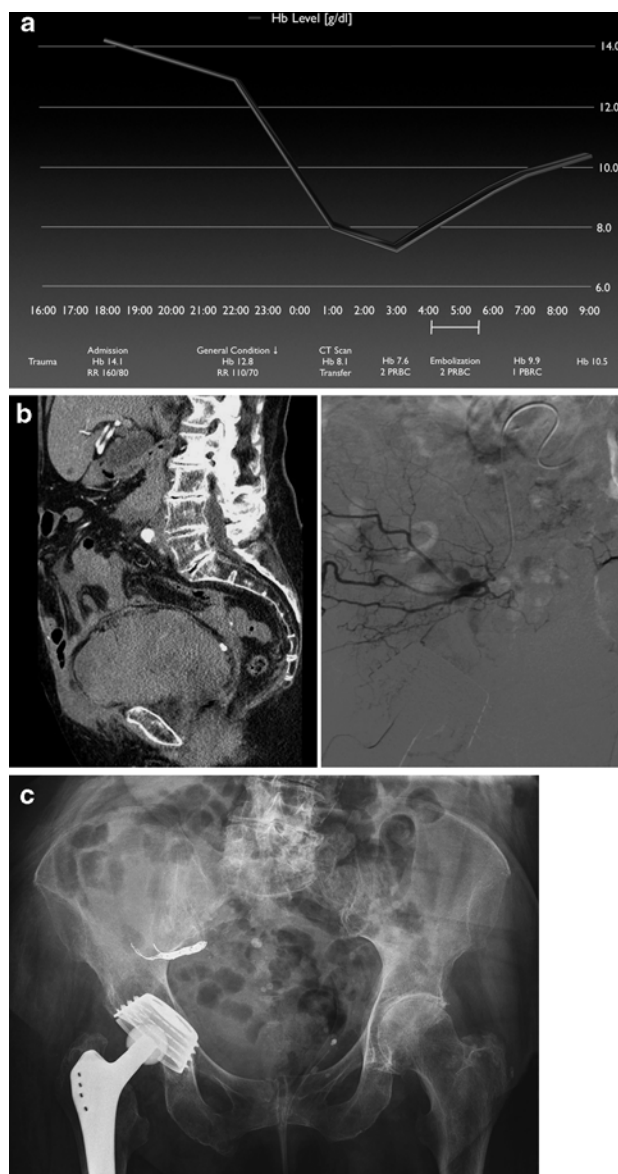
88-year-old female who sustained a fracture of the inferior pubic ramus on the right side after a simple fall (a). CT shows a massive pelvic hematoma. Angiography shows contrast medium extravasation of the right superior gluteal artery (b). X-ray control after successful embolization. Mind the bladder displacement to the left side due to the hematoma (c)
